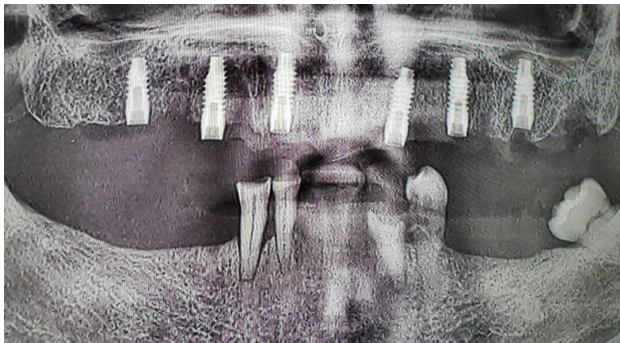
Post-operative RX orthopantomography.
